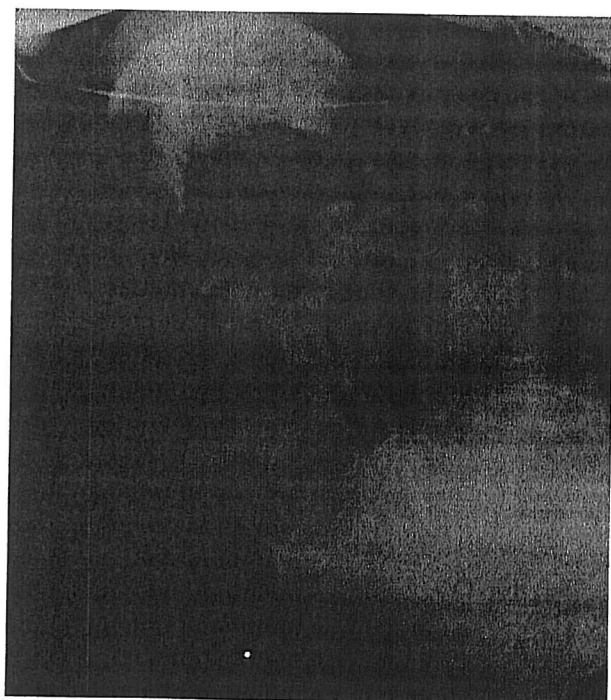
X-ray showing the head out of alignment, which results in nonalignment or disarticulation of the TMD in the glenoid fossa.
